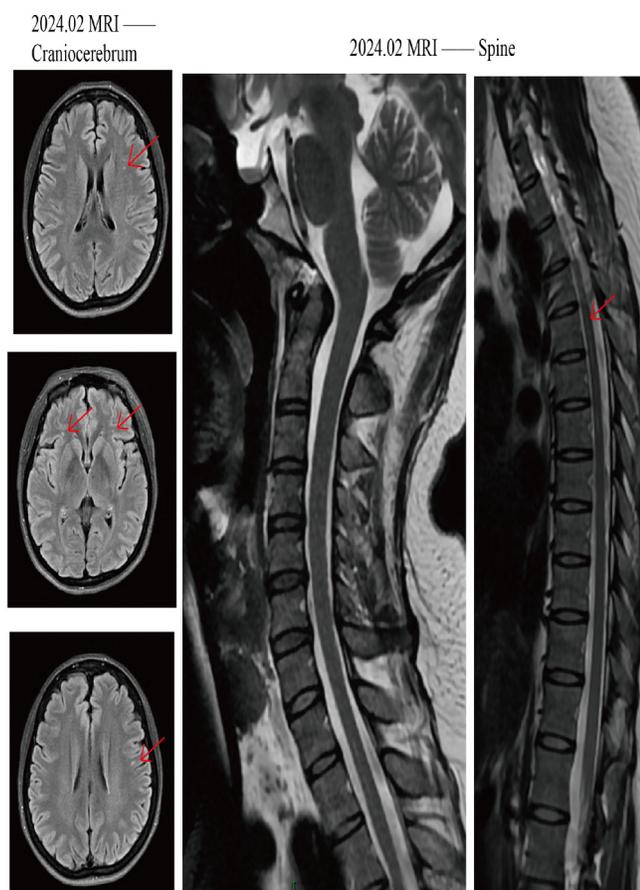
Axial and sagittal MR images of the brain and whole spine obtained on February 29, 2024. Red arrows indicate areas of abnormal white matter signals in the brain and high T2 signals within the spinal cord.
